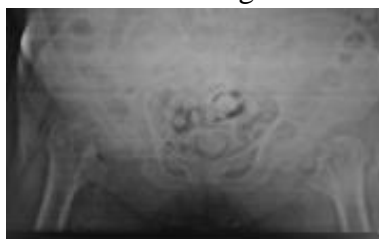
Trauma radiograph showing bilateral neck of femur fracture
